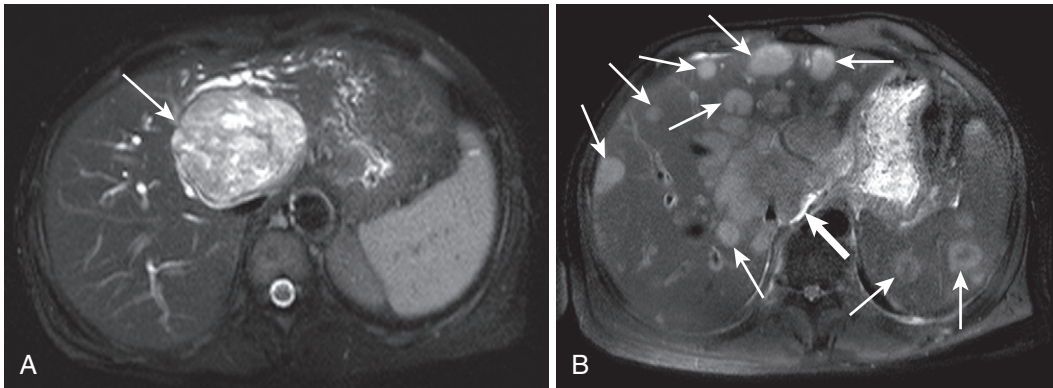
Moderately T2-weighted imaging shows bound water tissue contrast. A, The moderately T2-weighted image in a patient with a hepatic schwannoma (*arrow*) expresses the high water content often seen in schwannomas. Note the relatively higher tissue water content of the spleen compared with the liver—reflected by relative hyperintensity—serving as an indication of the tissue contrast of the bound water sequence. B, Even the relatively unhydrated lymphomatous lesions (*thin arrows*) with periportal lymphadenopathy (*thick arrow*) in a different patient with disseminated lymphoma are conspicuous on the bound water sequence owing to the high tissue contrast.
